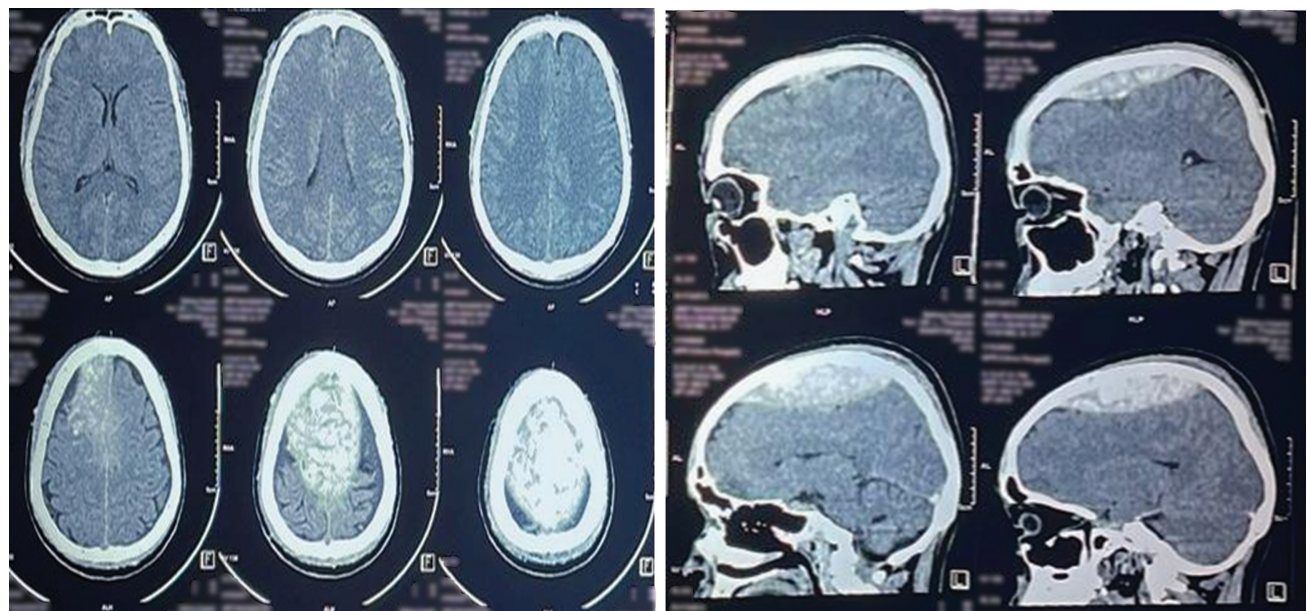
Computed tomography head (axial and sagittal cuts) showing vertex epidural hematoma.
